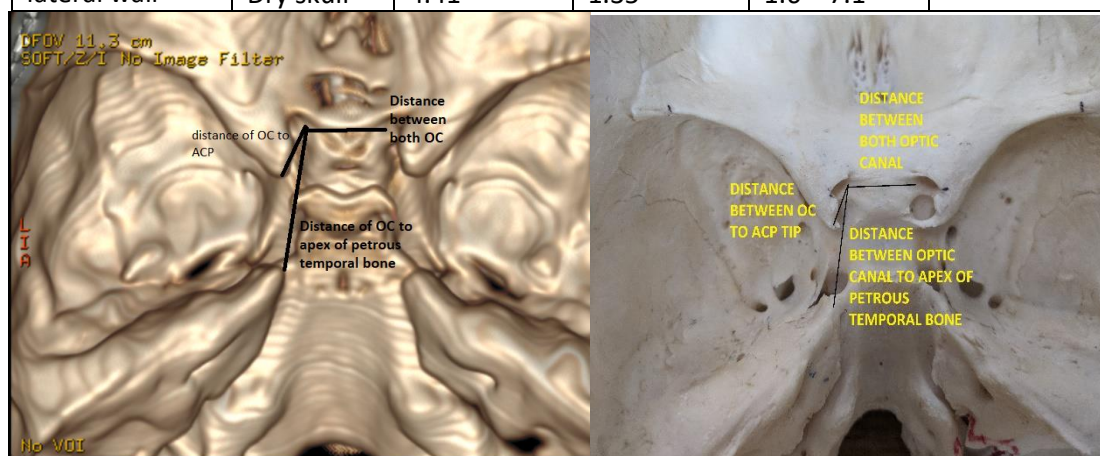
Measurement of optic canal in CT scan – (A) coronal section (B) Axial Section (C) 3D reconstructed image (D) Measurements in dry skull
